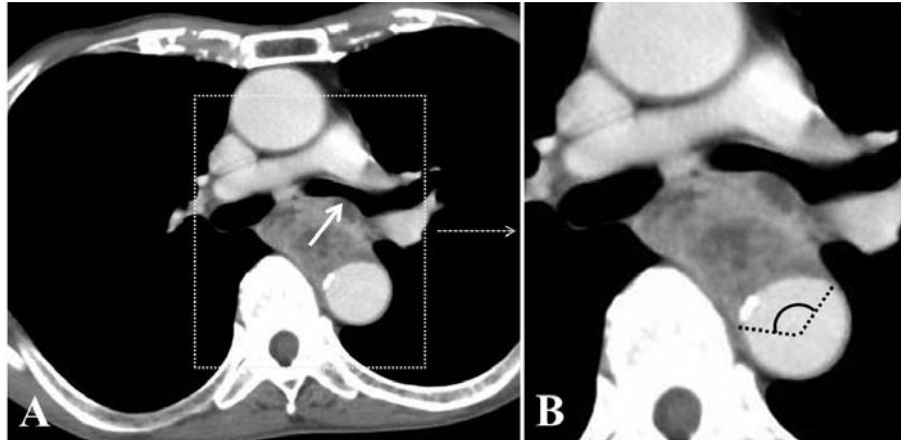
Chest computed tomography (CT) images of a representative patient with bronchial and aorta invasion. A: Chest CT image showing obvious deformation of the left main bronchus due to esophageal cancer (solid arrow). B: Chest CT image of the same patient showing that the Picus angle exceeded  $90^\circ$ , without a fat layer between the esophageal cancer and thoracic aorta.
